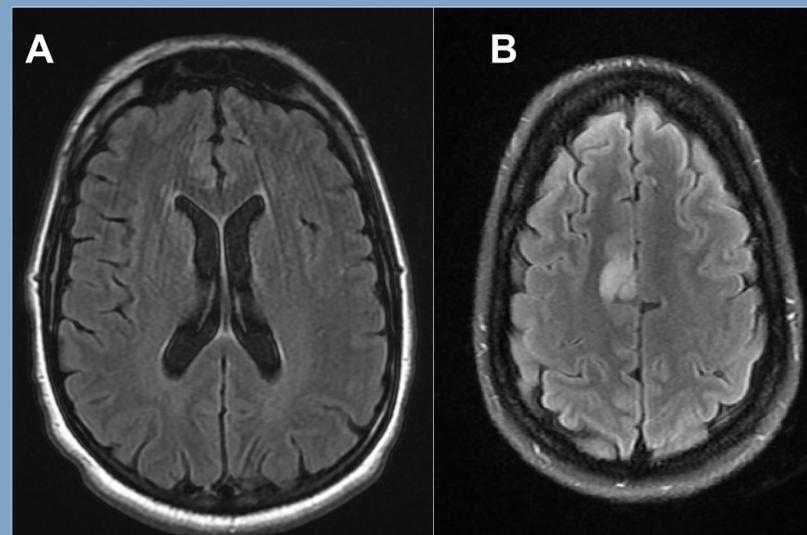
A) Axial T2 FLAIR brain MRI in this patient without acute abnormality, a common finding in Hashimoto encephalopathy. B) T2 FLAIR MRI brain finding in another patient with HE showing a focal area of hyperintensity in the right frontal lobe.
